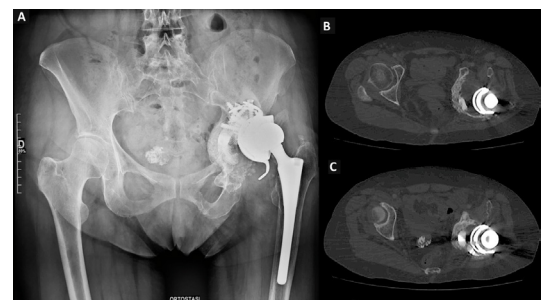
Preoperative X-ray (A) and CT scan (B,C) images showing triflange acetabular cup failure.
